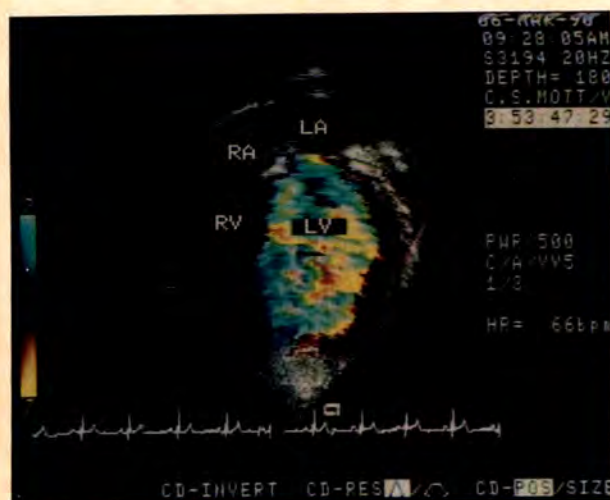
Color Doppler images at end-diastole (left) and end-systole (right) showing the technique used to determine left ventricular ejection fraction. The color sector is placed so as to include the entire left ventricle (LV), and the velocity scale has been decreased to the lowest possible setting. Note that the left ventricular cavity is filled with aliased (mosaic) color Doppler signals, whereas color Doppler signals arising from the left ventricular walls are pure red-blue (nonaliased). LA = left atrium; RA = right atrium; RV = right ventricle.
